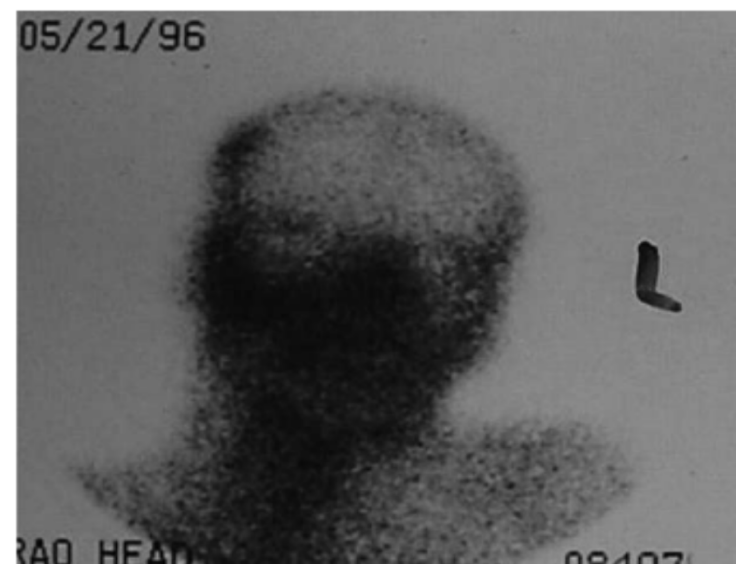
Case 2. Ga 67 scintigraphy shows increased uptake on the right mastoid, skull base, and lateral sinus suggestive of associated right skull base osteomyelitis with lateral sinus thrombophlebitis.
